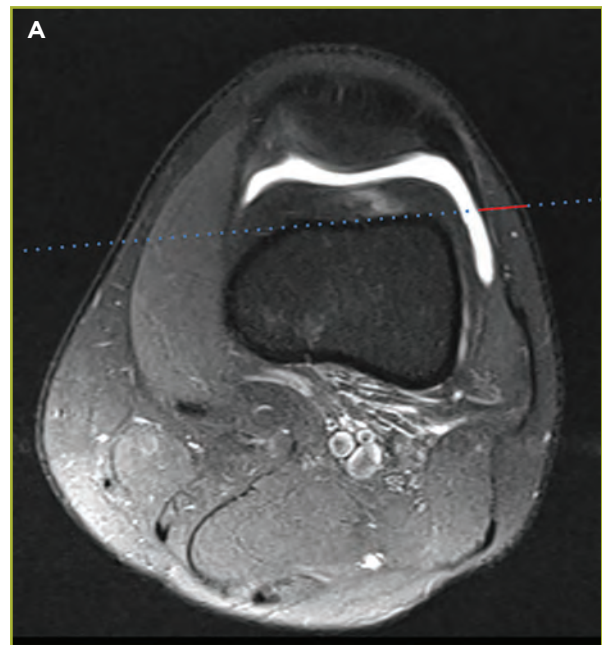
Magnetic resonance imaging, showing standard method of measuring the soft-tissue thickness at the superolateral approach of entry to the arthrocentesis site. A) Localizing software was used to find the corresponding axial cut at the superior aspect of the patella. The soft tissue over the capsule at the arthrocentesis site was measured, followed by a similar measurement one cut above and one cut below the initial point. Each cut progressed 3 mm through the plane imaged. B) Sagittal view used to identify the superior pole of the patella.
